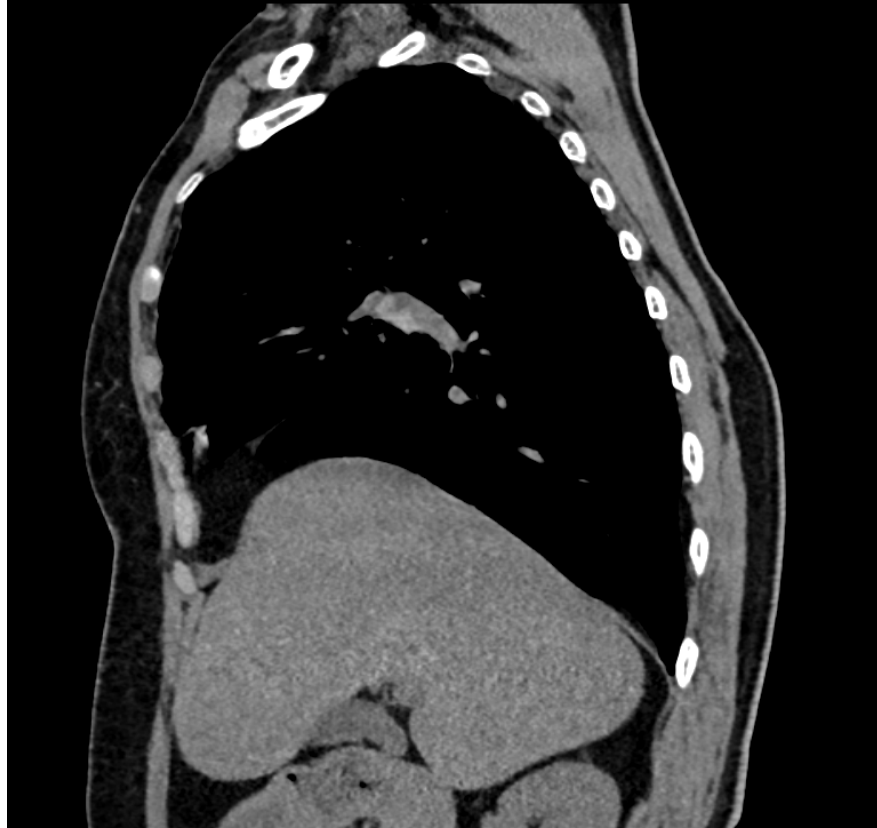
Plain CT of chest mediastinal window in sagittal plane
